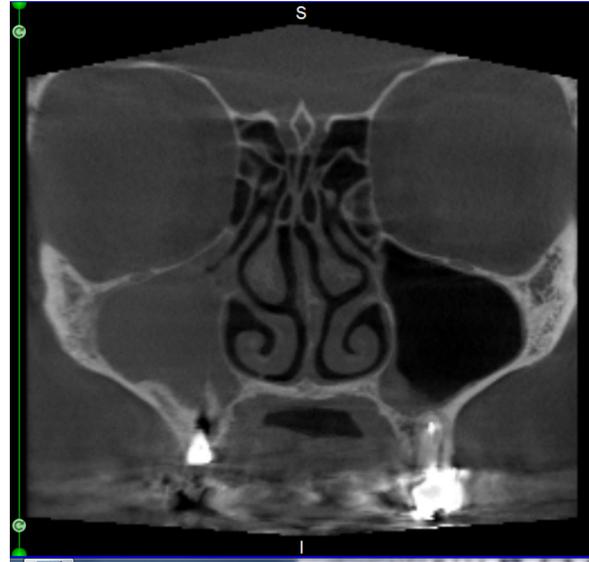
Cone-beam computed tomogram taken 7 days after operation, which shows mucosal thickening completely obstructing the right maxillary sinus cavity, with a patent ostium.
